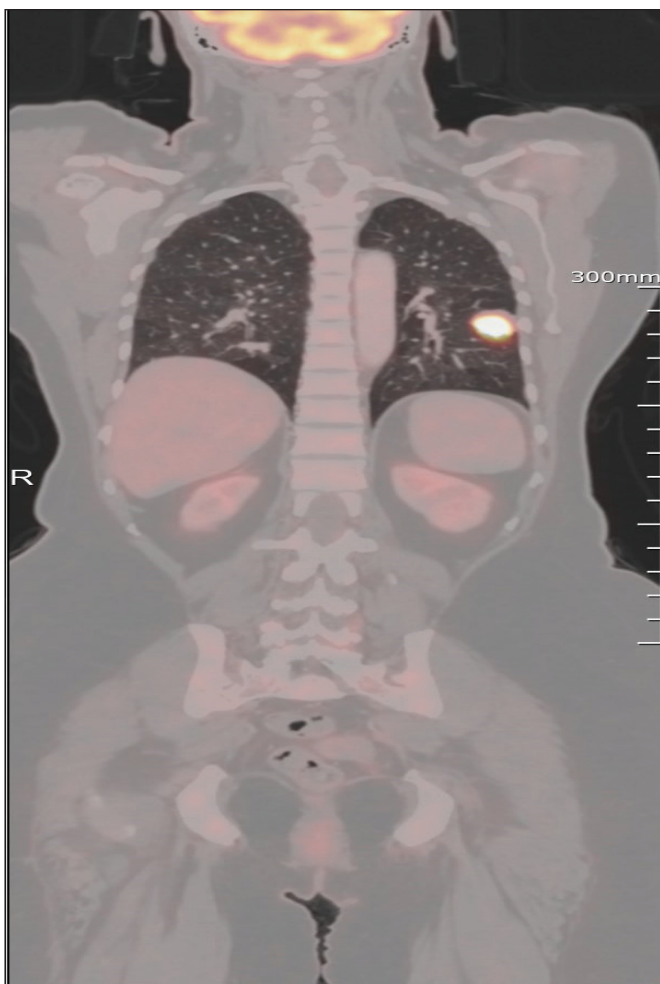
Showing pleural based nodular soft tissue lesion with spiculated margins noted in the lateral basal segment of lower lobe of left lung measuring 3.3 x 2.4 x 2.1 cm in size in PET-CT scan. The lesion is tethered to the left oblique fissure with fibrotic strands.
